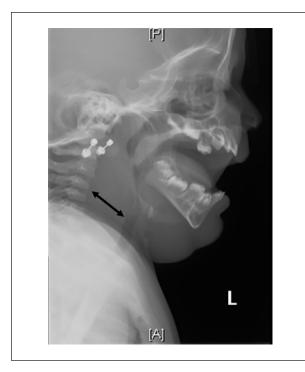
Lateral neck radiograph demonstrating prevertebral soft tissue swelling and narrowing of the upper airway.
